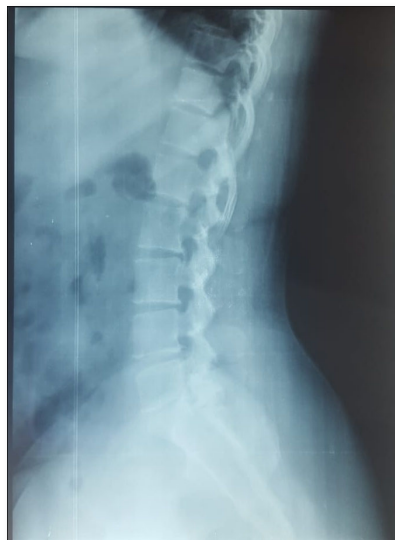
The normal lumbar spine x-ray.
